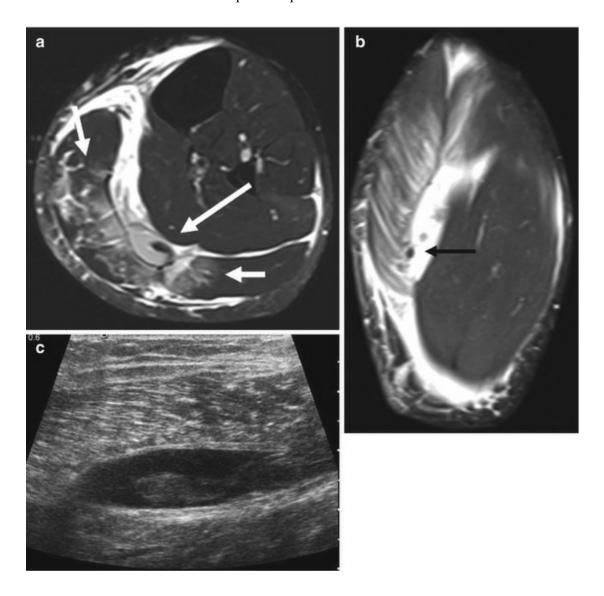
(a) Axial fat-suppressed T2-weighted MRI demonstrates fluid between the soleus muscle and the medial head of the gastrocnemius muscle. Irregular low signal intensity within the fluid collection represents the remnant of the ruptured plantaris tendon (long white arrow). Feathery edema involving both medial and lateral heads of the gastrocnemius is compatible with strain (short white arrows). (b) Coronal fat-suppressed T2-weighted MRI again demonstrates fluid between the soleus muscle and the medial head of the gastrocnemius muscle and irregular low signal intensity within the fluid collection that represents the remnant of the ruptured plantaris tendon (arrow). (c) Longitudinal ultrasound demonstrates the same
